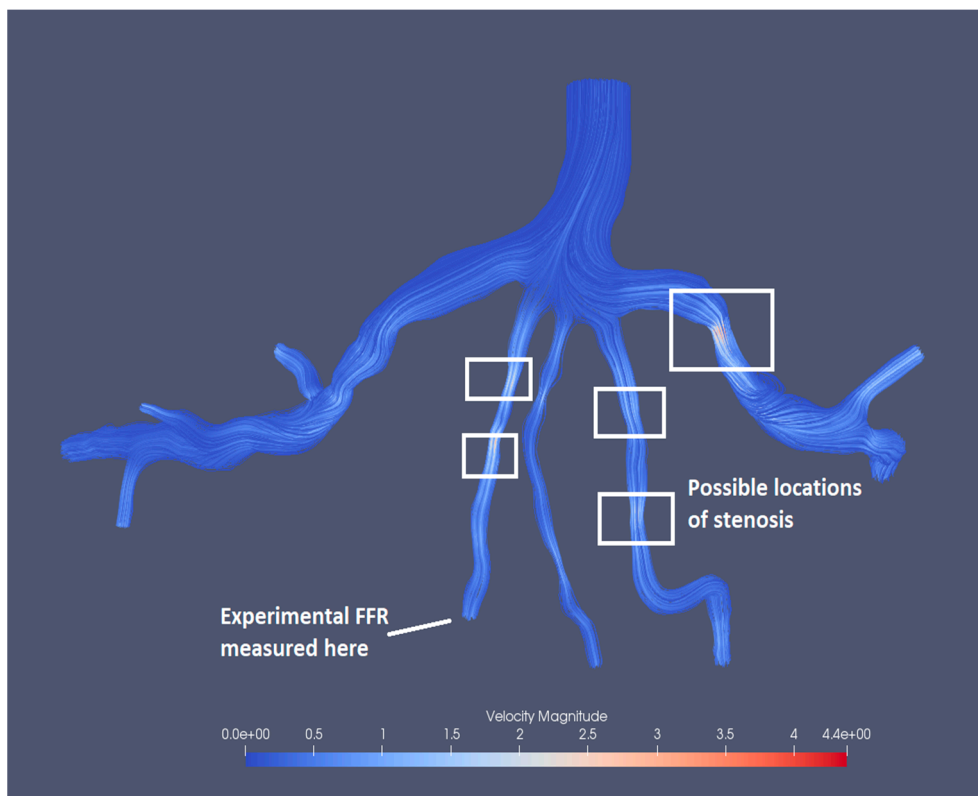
Visualization of velocity streamlines in the CT 209 model.
